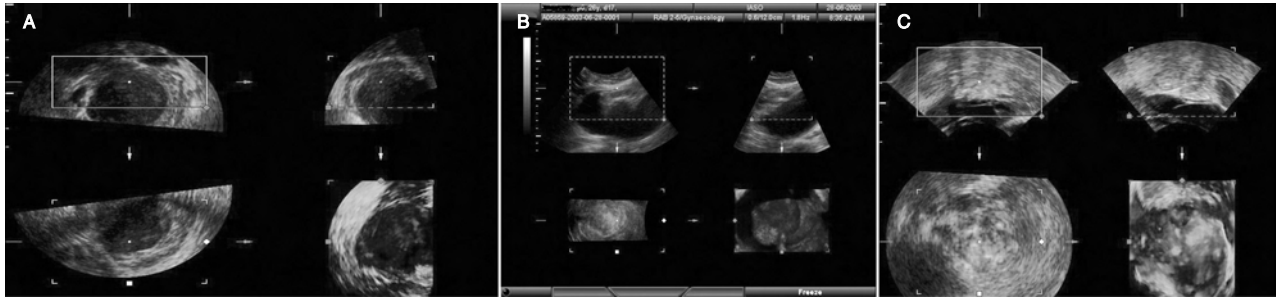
3D-US acquisitions of endometrioma (A), dermoid cyst (B), and haemorrhagic cyst of corpus luteum (C), that were allocated a high score by using sonographic criteria. B-mode-US, 3D-US, 3DPD-US scores were 5, 9, and 9 for A, 10, and 10 for B, and 6, 9, and 9 for C.
